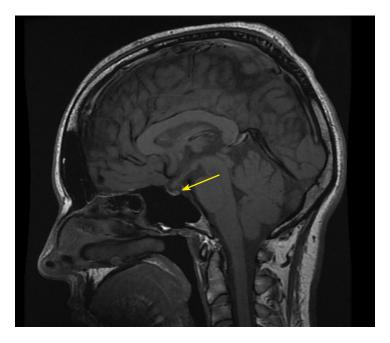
Non-contrast MRI of the head, T1 WI, sagittal projection. MR picture of partially "empty" Turkish saddle. No signal from posterior pituitary (changes indicated by arrow).
